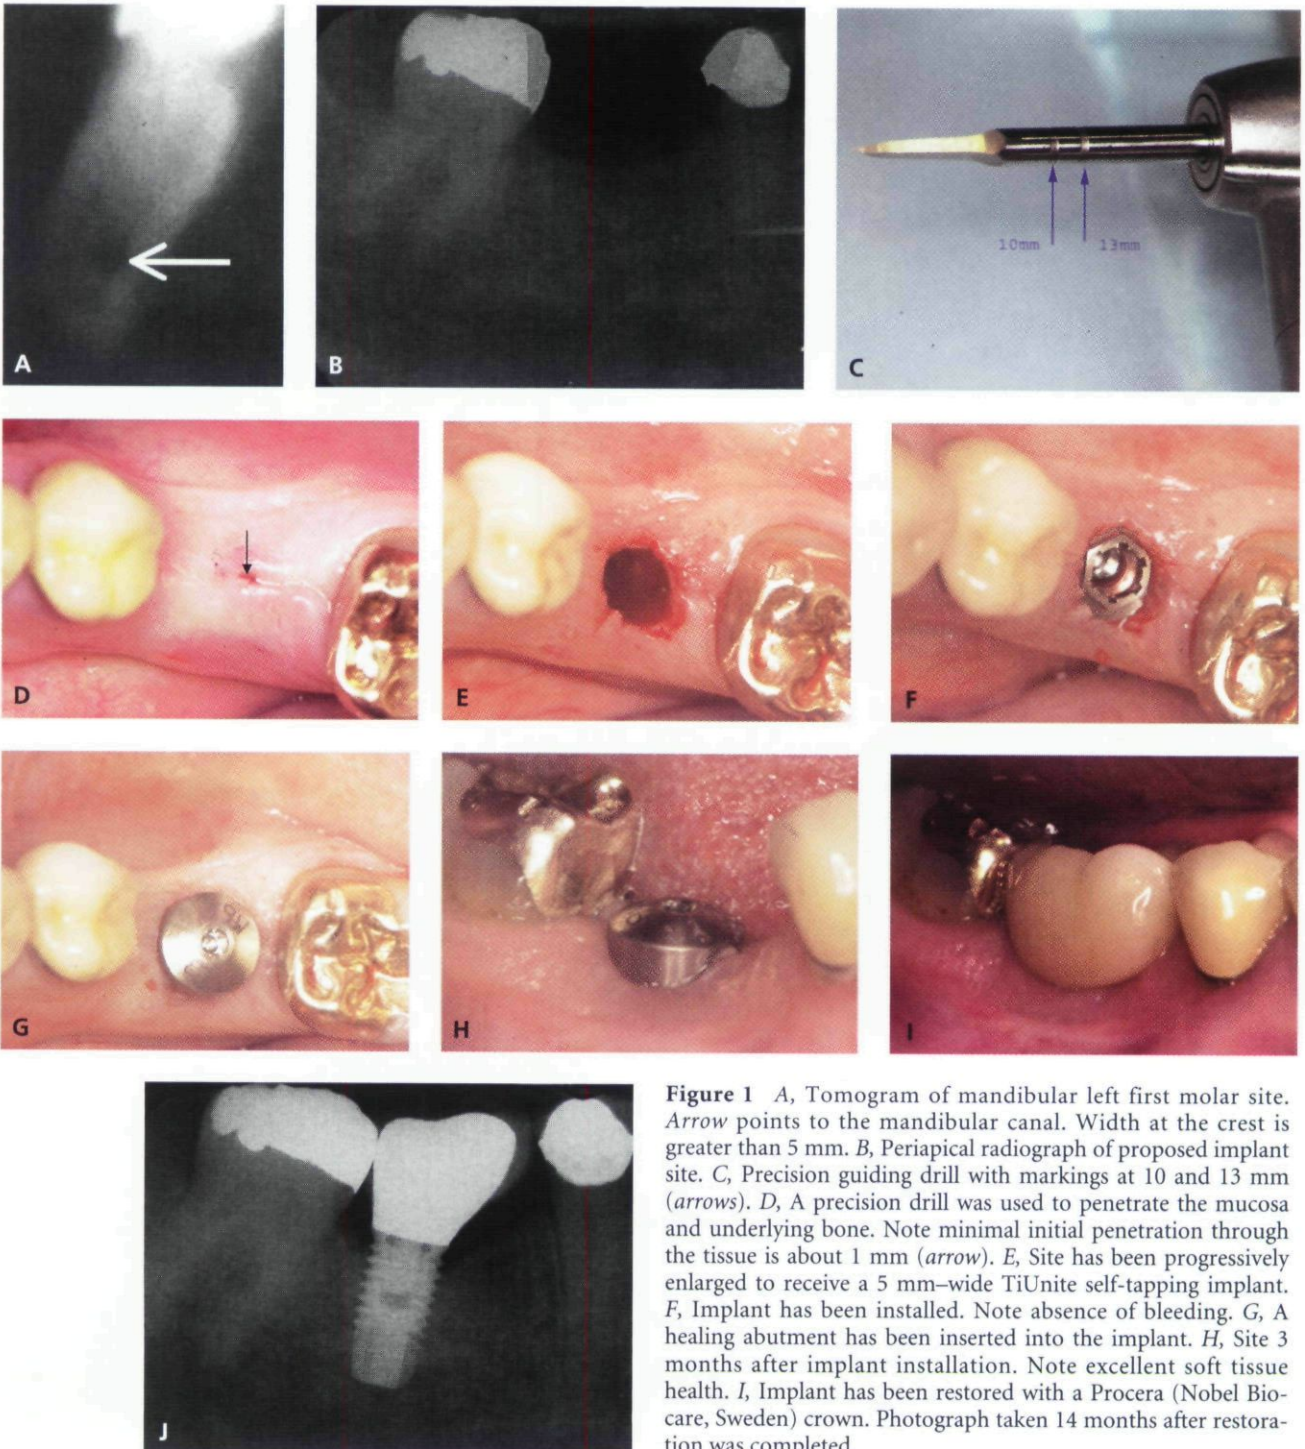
A, Tomogram of mandibular left first molar site. Arrow points to the mandibular canal. Width at the crest is greater than 5 mm. B, Periapical radiograph of proposed implant site. C, Precision guiding drill with markings at 10 and 13 mm (arrows). D, A precision drill was used to penetrate the mucosa and underlying bone. Note minimal initial penetration through the tissue is about 1 mm (arrow). E, Site has been progressively enlarged to receive a 5 mm-wide TiUnite self-tapping implant. F, Implant has been installed. Note absence of bleeding. G, A healing abutment has been inserted into the implant. H, Site 3 months after implant installation. Note excellent soft tissue health. I, Implant has been restored with a Procera (Nobel Biocare, Sweden) crown. Photograph taken 14 months after restoration was completed.
